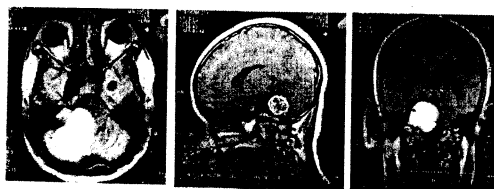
MRI showing tumour in the posterior cranial fossa (cerebellopontine angle tumour)
